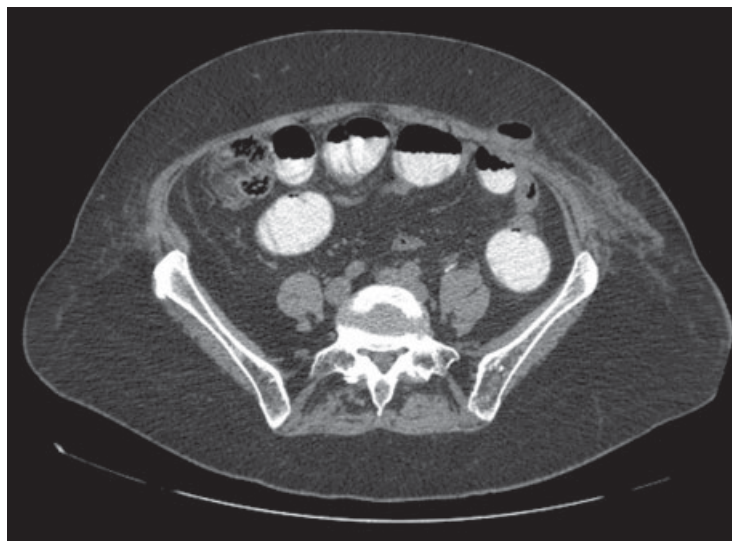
CT with oral contrast, axial view.
